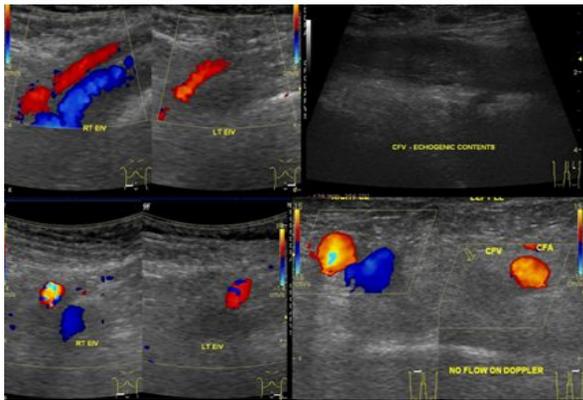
Sagittal and axial grey scale and color Doppler images showing presence of thrombus as echogenic contents and absent flow in the left Common femoral vein (CFV) which was seen extending upto the External Iliac Vein (EIV).
